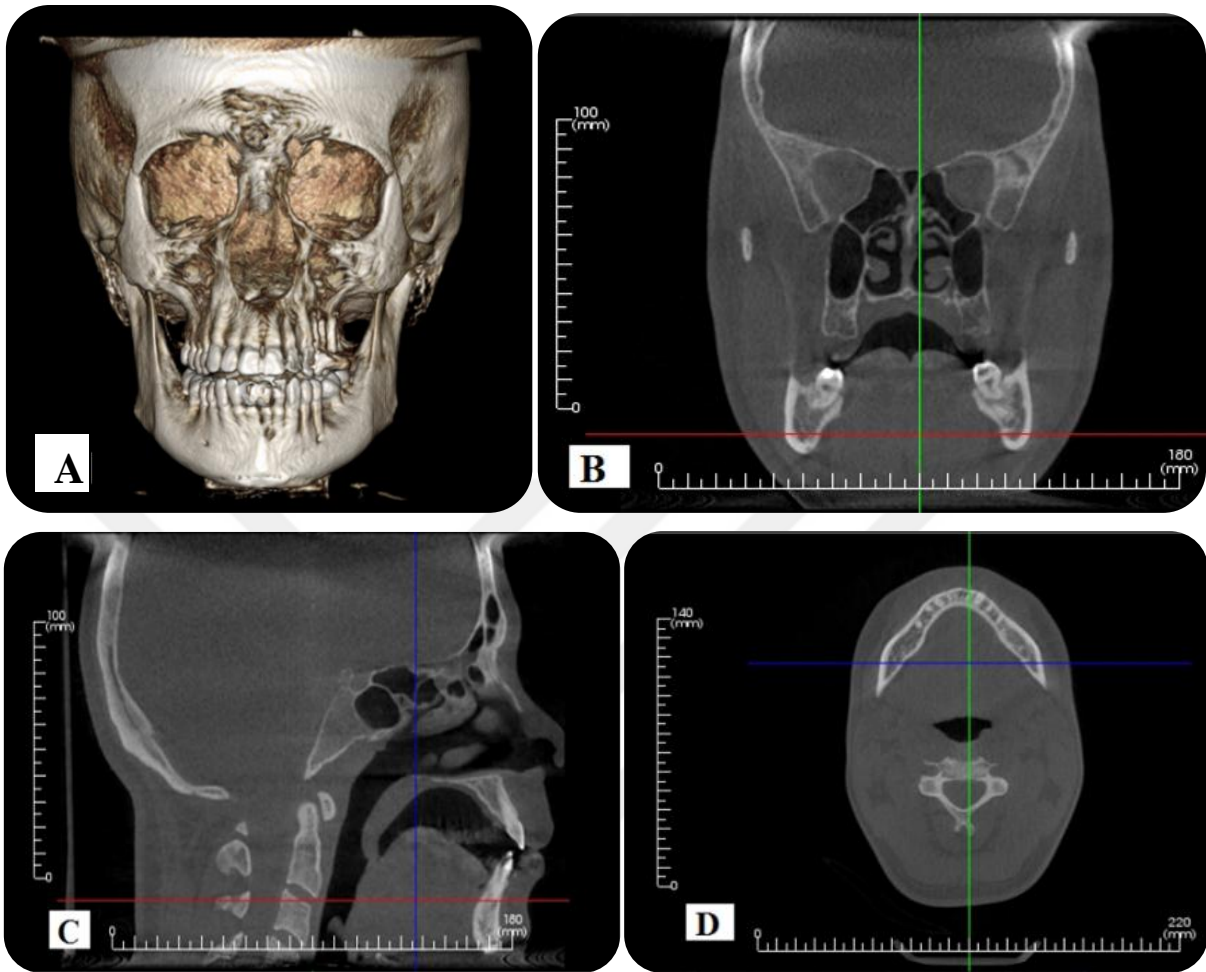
Standard Display Modes of CBCT. A: Volumetric 3-D representation of hard tissue. B: Representative coronal image. C: Representative sagittal image. D: Representative axial image (Images obtained with i-CAT® Model 17-19; CBCT Imaging Unit: InVivoDental5 Version 5.2 Anatomage, software): Dentomaxillofacial Radiology Department; Faculty of Dentistry- University of Yeditepe.
